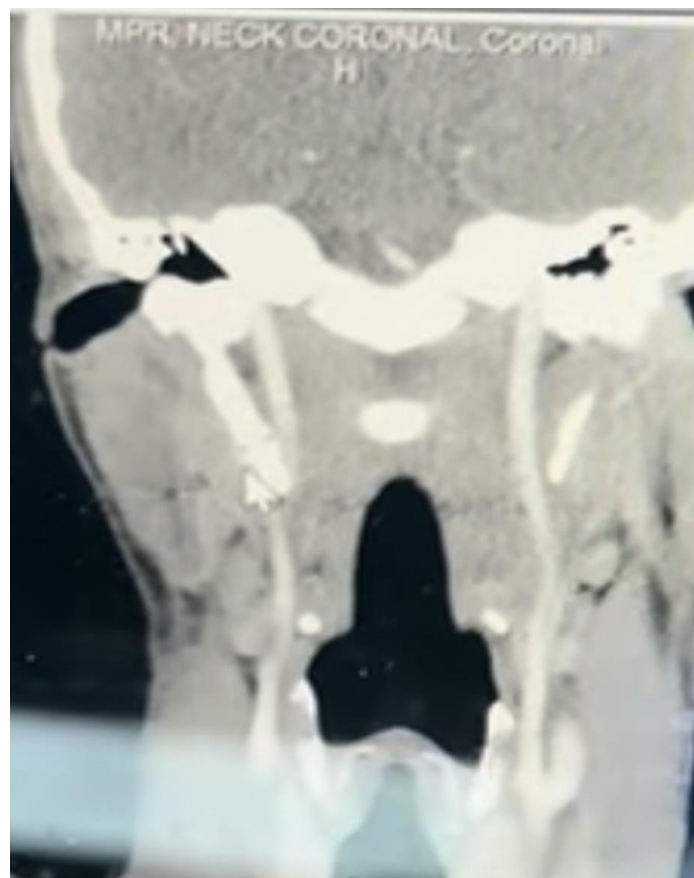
Computed tomography image with contrast demonstrates the approximation of the calcified stylohyoid ligament and the right carotid artery.
